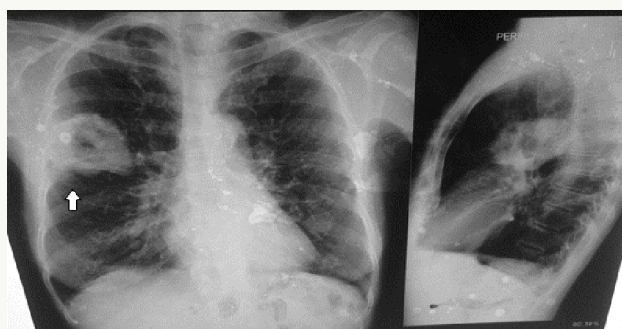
PA and lateral chest X-ray – Heterogeneous opacity with cavitation in right upper middle lobe (arrow).
